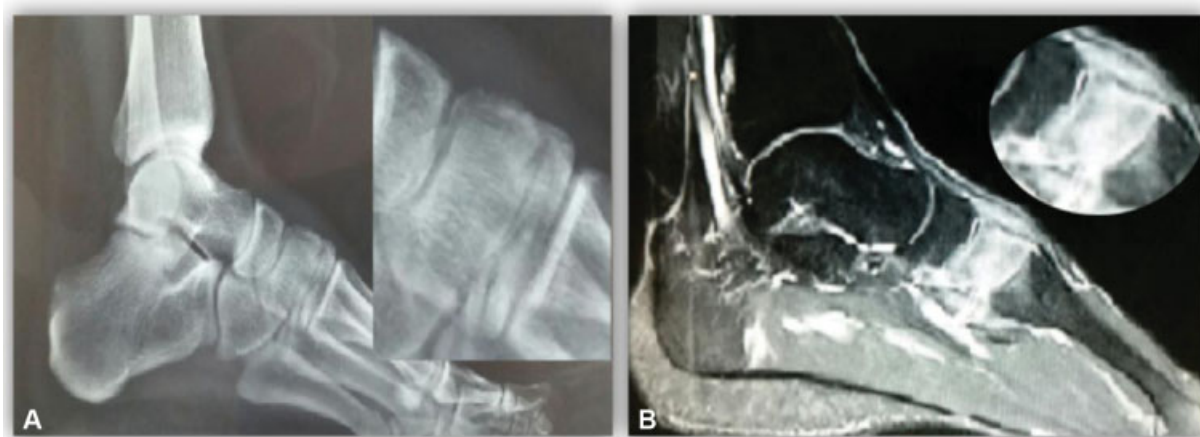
(A) Radiographic examination in profile view. A radiolucent line can be seen in the dorsal cortex of the cuneiform. (B) T1-weighted sagittal magnetic resonance imaging demonstrating a mixed pattern of a diffuse hypersignal alternating with areas of hyposignal.
